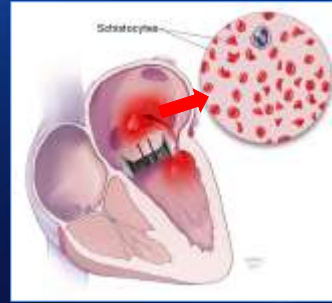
Fragmentation of red blood cells (RBCs) during mitral valve repair. The echocardiogram shows the mitral valve area with turbulent flow (color Doppler) and the presence of schistocytes (fragmented RBCs) in the blood. The echocardiogram shows the mitral valve area with turbulent flow (color Doppler) and the presence of schistocytes (fragmented RBCs) in the blood.
